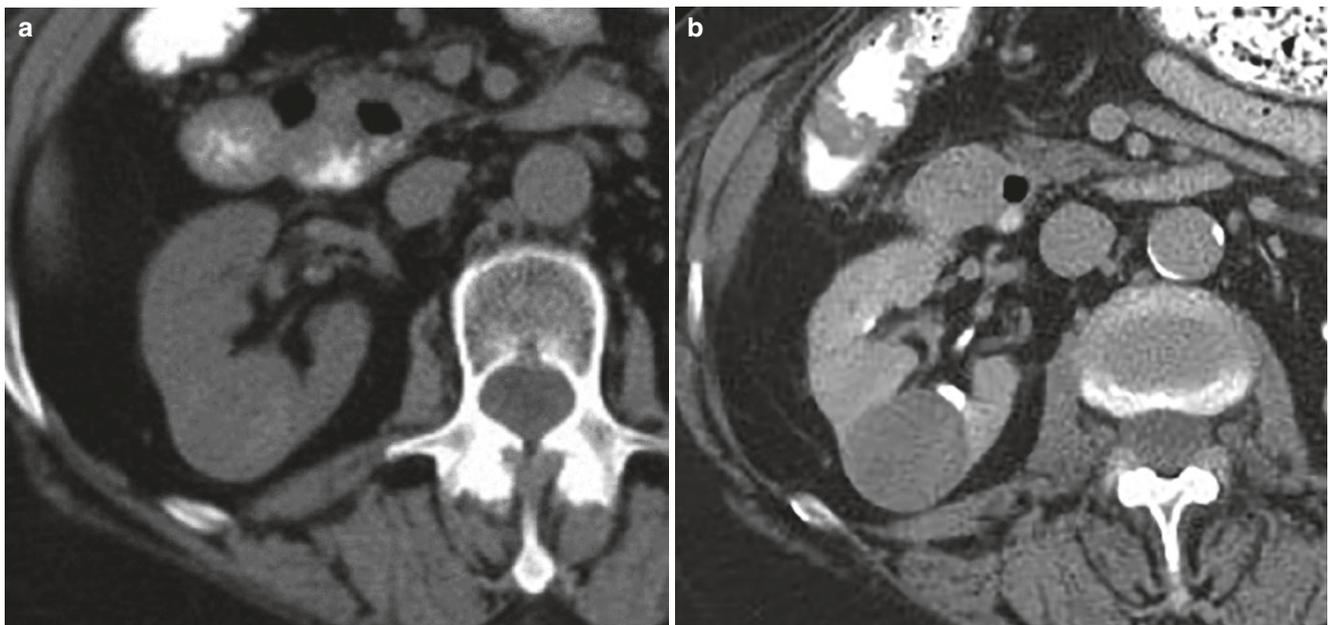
Papillary renal cell carcinoma. Unenhanced (a) and excretory phase (EP) contrast-enhanced (b) axial CT images demonstrate a mildly heterogeneous hypoenhancing papillary cancer in the posterior aspect of the mid right kidney
